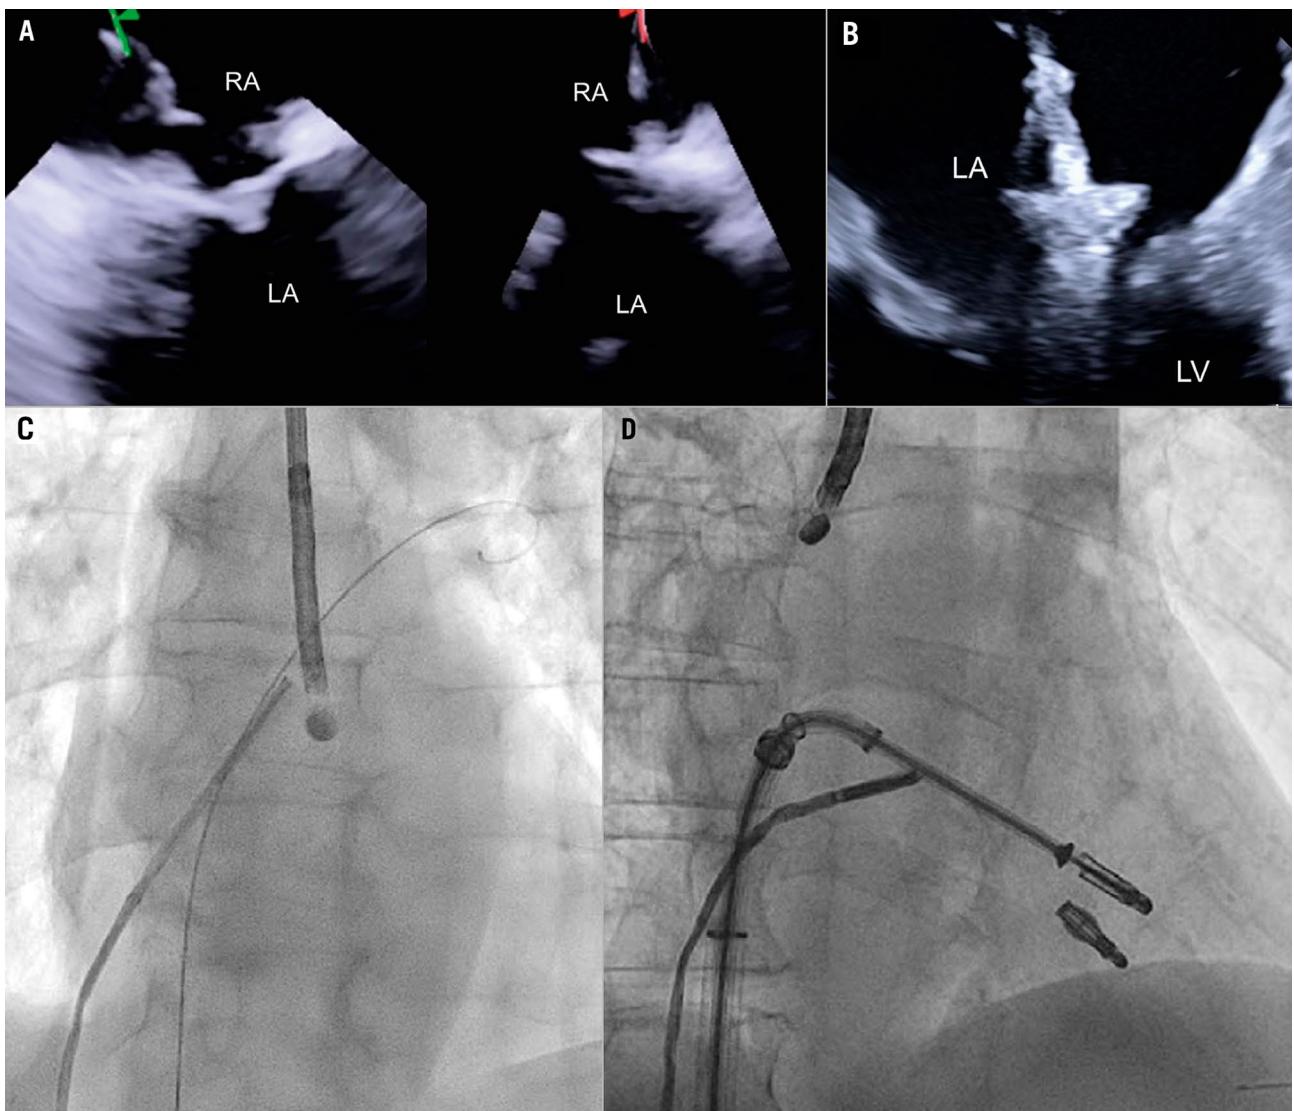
ICE-guided transseptal puncture. A) Transseptal puncture using biplanar imaging with the ICE catheter retroflexed in the middle of the RA. Needle tenting is seen simultaneously in two dimensions. B) Position of the delivery catheter over the diseased mitral valve. C) After wire placement and septum predilatation, the ICE catheter is moved into the LA following the trajectory of the stiff wire. A paediatric TOE probe without 3D capacity is inserted into the oesophagus. D) Position of the ICE catheter below the TEER system to avoid shadowing artefacts. 3D: three-dimensional; ICE: intracardiac echocardiography; LA: left atrium; RA: right atrium; TEER: transcatheter edge-to-edge repair
